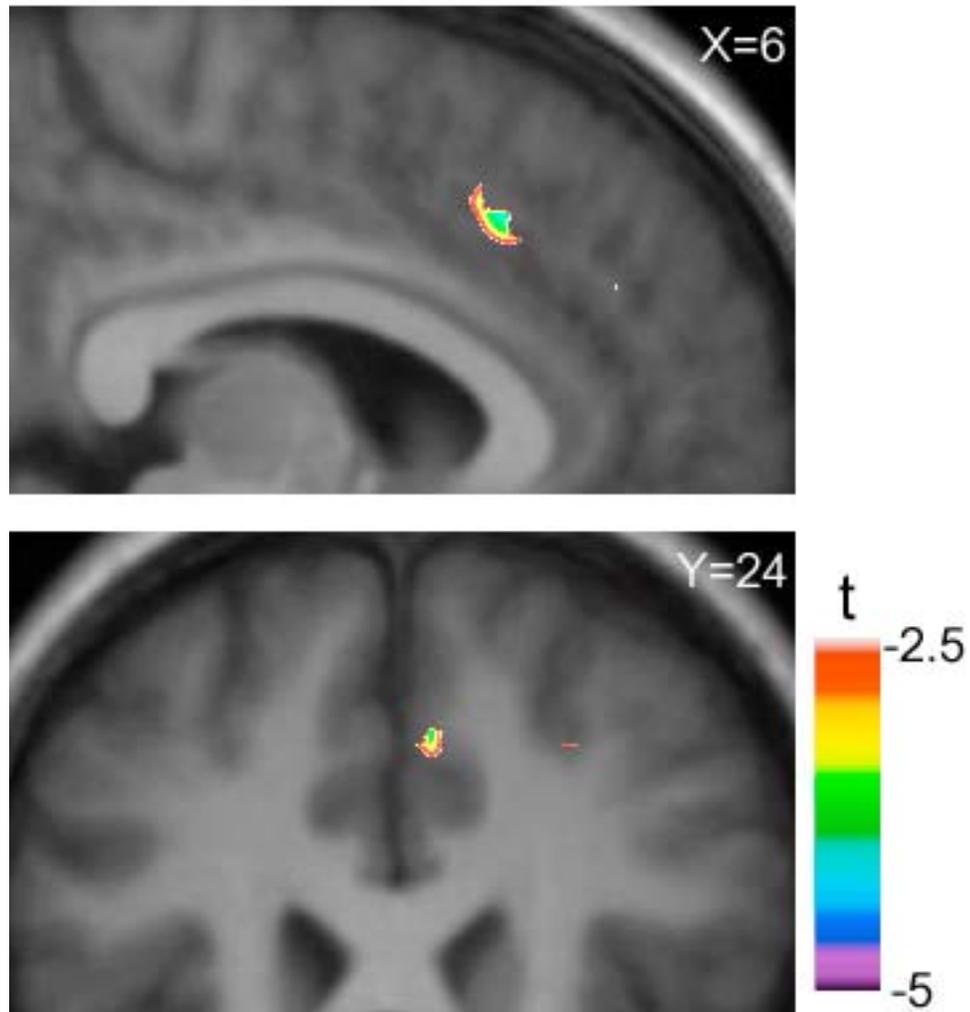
Active vs. control tasks condition. Sagittal ($X = 6$) and coronal ($Y=24$) section of the statistical parametric map of the change in $[^{11}\text{C}]\text{FLB 456 BP}$ overlaid upon the average MRI of all subjects in standardized stereotaxic space. The figure displays the significant area of dopamine changes during active task performance compared to the control task at the level of dorsal ACC.
